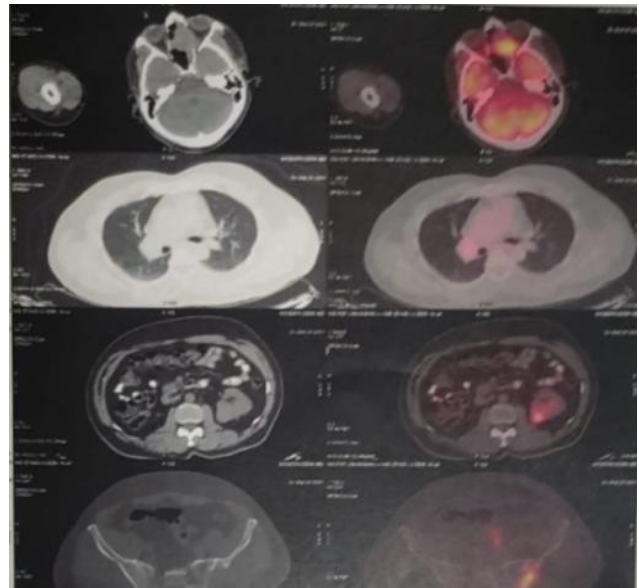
PET CT showing increased uptake suggestive metastasis to PNS, chest, iliac crest, and left adrenal glands.
